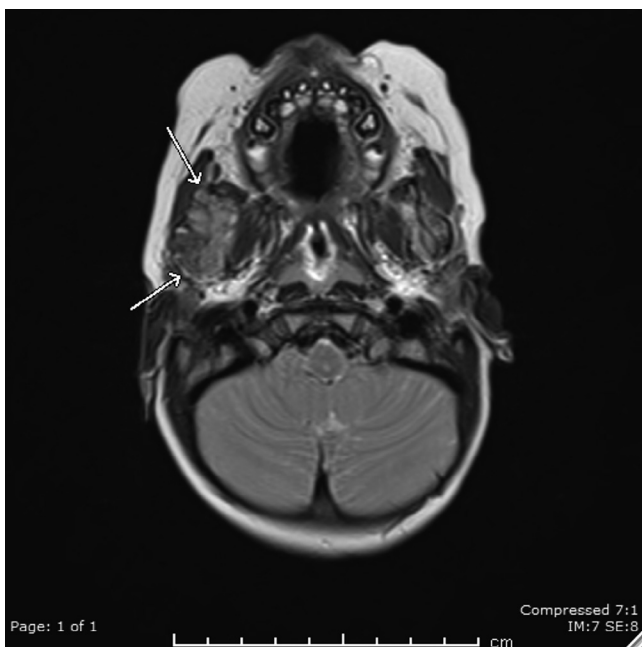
Axial T2-weighted image shows mildly increased T2 signal within the right mandibular soft tissue mass.
